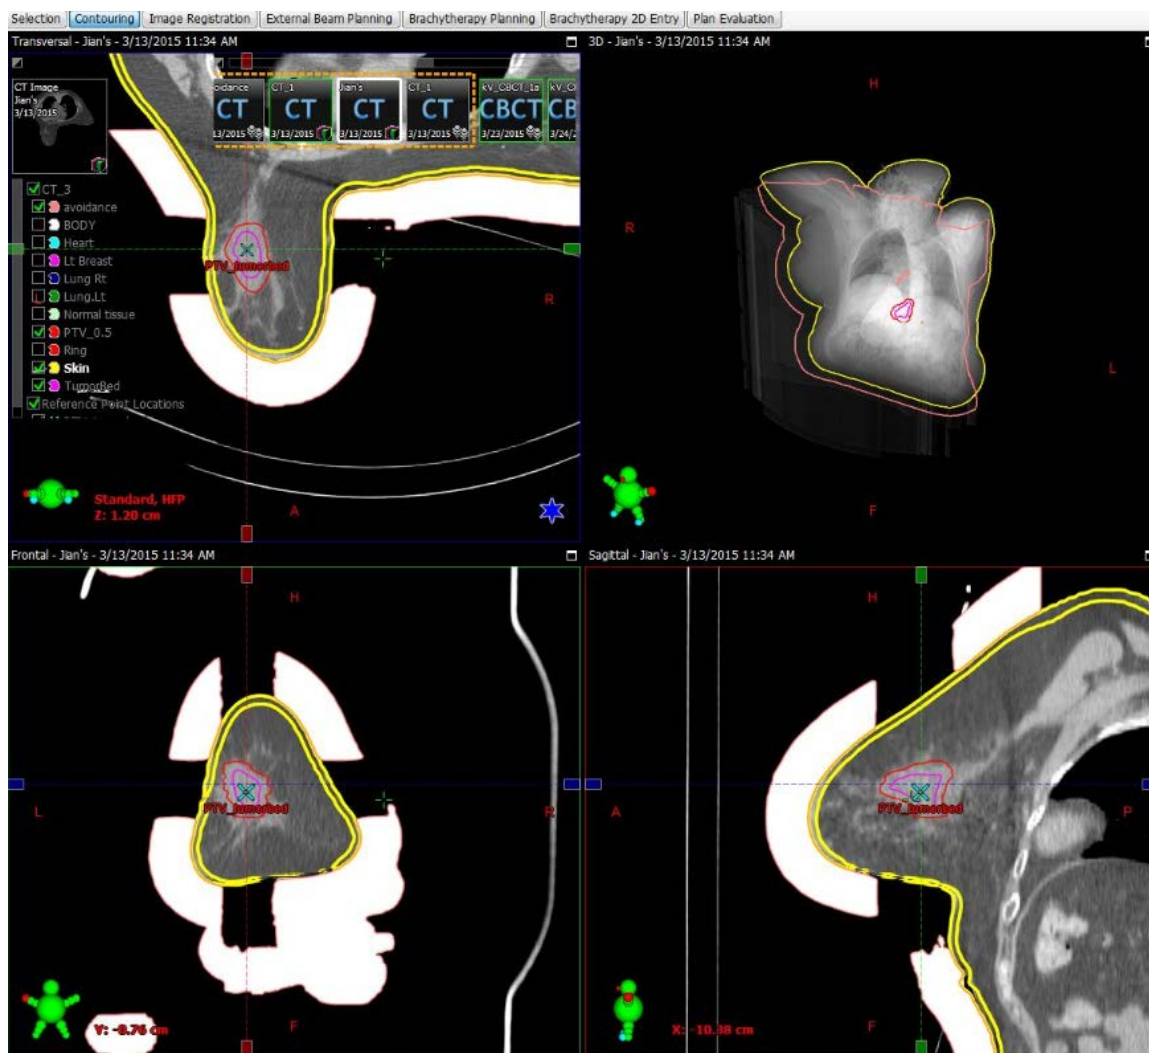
Contouring of the treatment plan. GTV was defined as gross tumor bed visible in all slices of CT images. The PTV was based on an automatic 0.5 cm margin around the GTV. A virtual structure named “avoidance structure” was created (shown in white) on top of the skin with a thickness of 3 cm to serve as a collimator. We assigned a CT value of 3000 HU to this structure, which is the maximum HU allowed in Acuros algorithm. Top left: transverse view. Top right: 3-D view. Bottom left: corona view. Bottom right: sagittal view.
